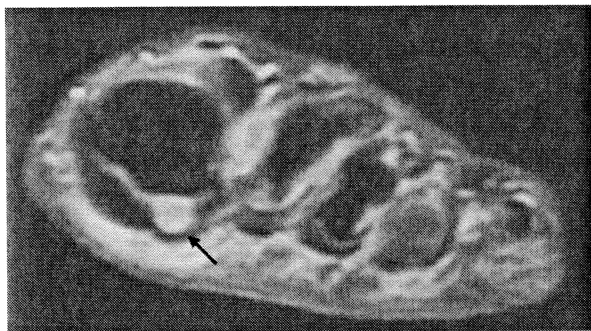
(a) T2-weighted MR image in the coronal plane of a 62-year-old woman with a moderate bone marrow edema (arrows) in the lateral sesamoid. Main pathology was an osteonecrosis of the head I.MTP after surgery because of hallux valgus.
